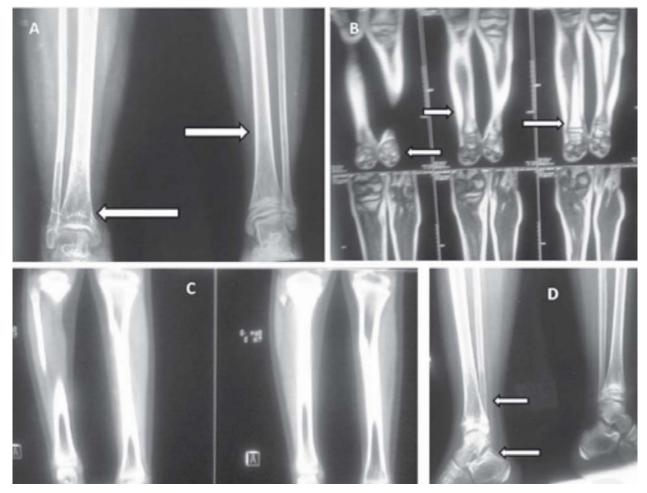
A: X ray of bilateral tibia and fibula with ankles depicting healing fracture of tibia with distal-tibial cystic lesion with hohmogeneous ground glass matrix and cloud of smoke calcification, generalized osteopenia of foot bones with cortical thinning of leg bones. B: T2 weighted images of MRI depicting heterogenous hyperintensity in distal third of right tibia and small heterogeous hyperintensities in ankle bones. C: A section from computed tomography scan showing ground glass appearance of lower end of tibia. D: Lateral X ray depicting distal tibial cystic lesion, healing fracture and osteopenia of foot bones especially talus and calcaneus.
